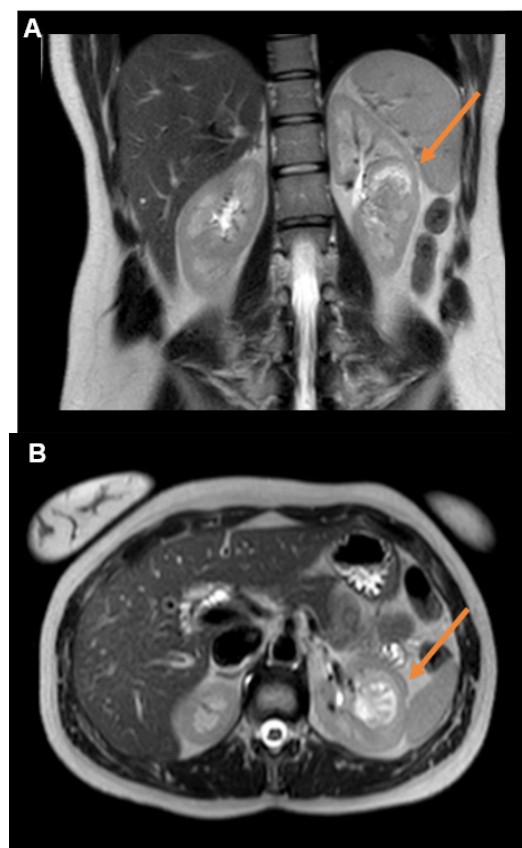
MRI of the abdomen showing a 32mmx29mmx27mm centrally located, solid kidney tumor in the middle pole of the left kidney (orange arrow); A frontal plane; B transversal plane.
